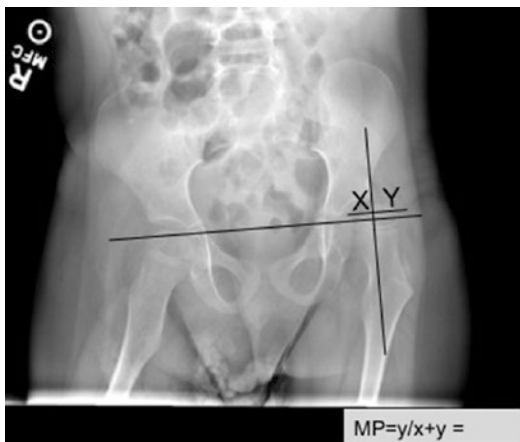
Preoperative radiograph of a 5-year-old child with CP (GMFCS level V); migration percentage of the left hip 80%
